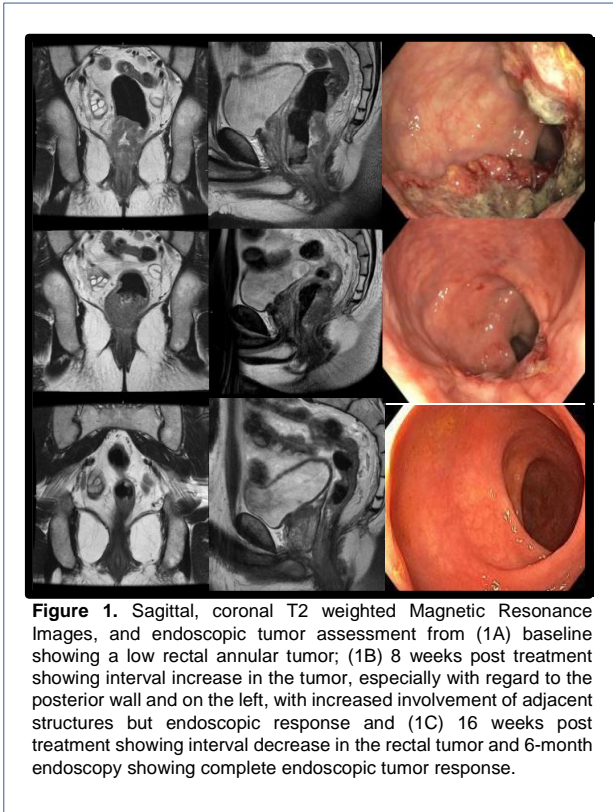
Sagittal, coronal T2 weighted Magnetic Resonance Images, and endoscopic tumor assessment from (1A) baseline showing a low rectal annular tumor; (1B) 8 weeks post treatment showing interval increase in the tumor, especially with regard to the posterior wall and on the left, with increased involvement of adjacent structures but endoscopic response and (1C) 16 weeks post treatment showing interval decrease in the rectal tumor and 6-month endoscopy showing complete endoscopic tumor response.
